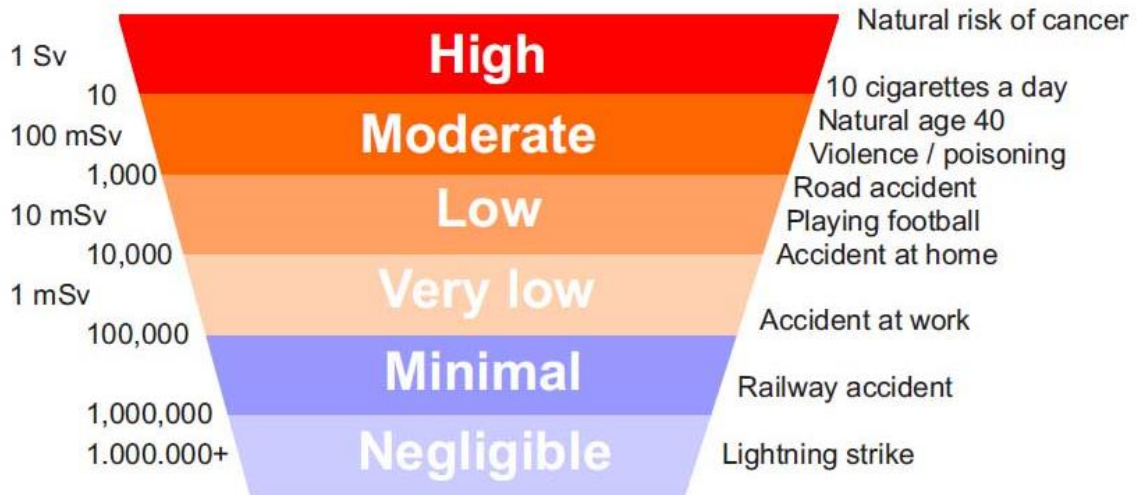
Comparative risk of exposure to X-rays.
